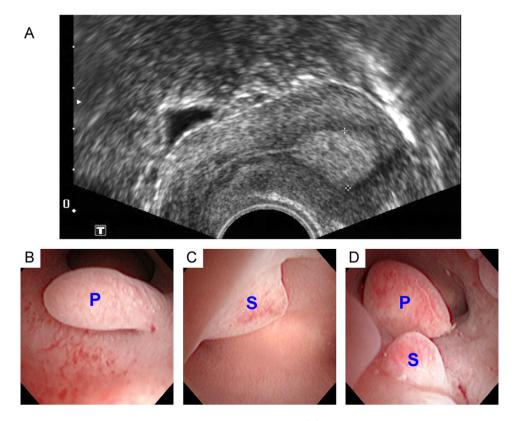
(A) Transvaginal ultrasound reveals focally thickened endometrium; (B) office hysteroscopy demonstrates a pedunculated type endometrial polyp (P) with the angle of polyp surface to endometrium less than 90°; (C) a sessile type endometrial polyp (S) with an angle of 90° or wider; and (D) multiple endometrial polyps containing both types.
